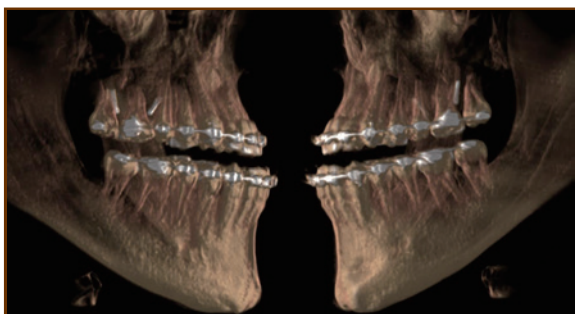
Pre-surgical computed tomography scan showing the underbite before surgery (Clinical images from personal collection)
